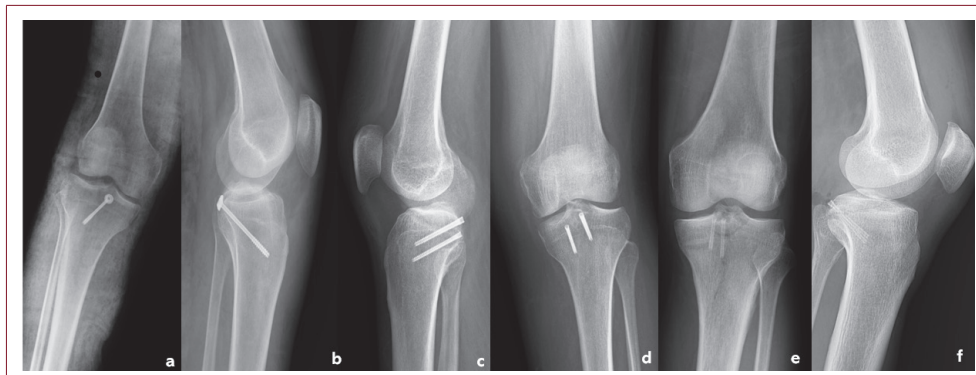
Tibial posterior cruciate ligament avulsion fractures treated with open reduction and internal fixation with various screw types are shown in representative postoperative radiographs. (a,b) Anteroposterior and lateral views of cannulated screw fixation. (c,d) Anteroposterior and lateral views of headless compression screw fixation. (e,f) Anteroposterior and lateral images of magnesium screw fixation.
